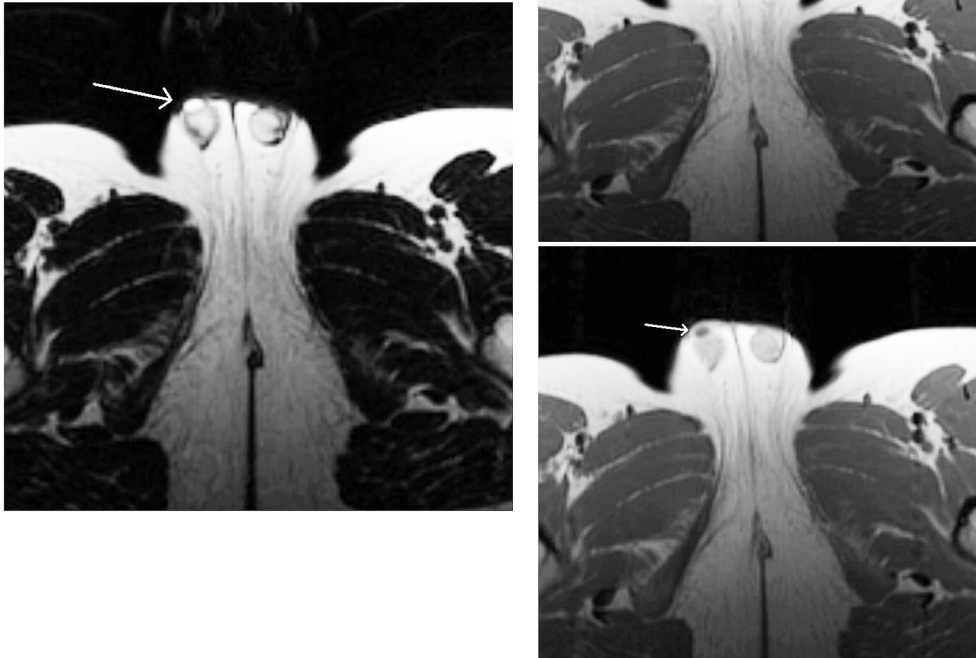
A 10-year-old boy with torsion of right testicular appendage. T2-weighted image on the left picture with white arrow is demonstrative for TAT and T1-weighted image with contrast media (right bottom) shows no contrast enhancement in the appendage.
